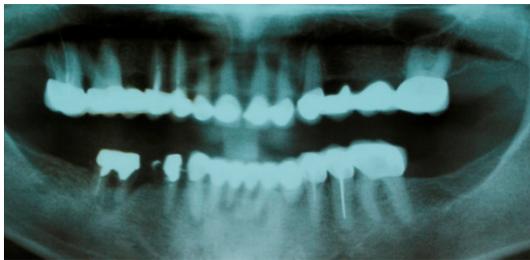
Panoramic X-ray before treatment
